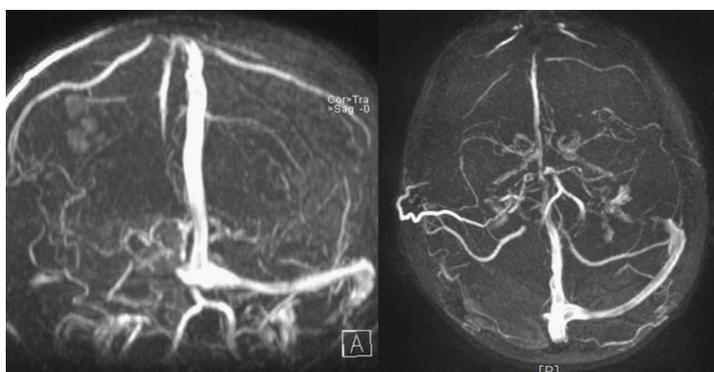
Angio-magnetic resonance imaging three dimensional reconstruction of the dural sinus system. It is not possible to appreciate any signal within the right transverse sinus as it happens for dural sinus occlusion. Notice the patency of the contralateral dural sinus complex.
